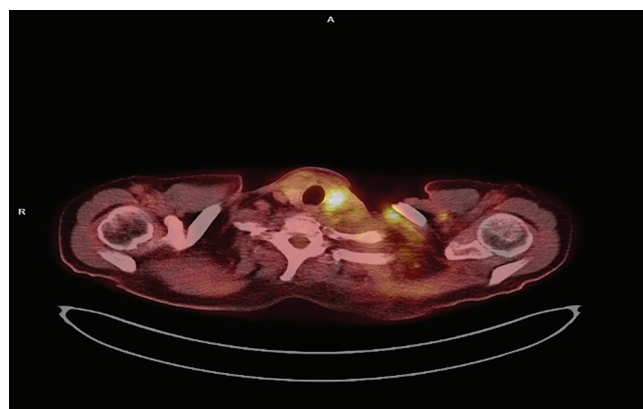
^{18}F -FDG PET/CT fusion image of thyroid lesion
